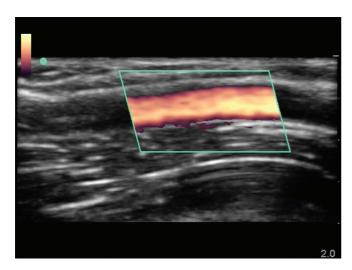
Color Power Doppler (CPD) of the radial artery. Note that there is no velocity or directionality in CPD, but just the presence and amount of moving particles. This is inferred by the amplitude of the frequency shift- the higher the amplitude, the greater the signal intensity, and thus the greater amount of moving particles.
